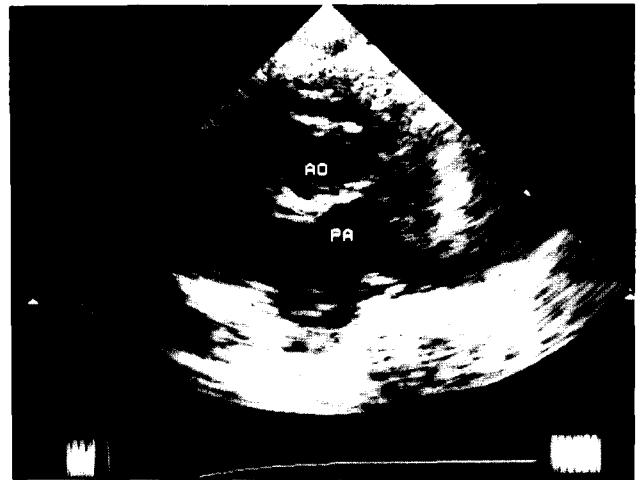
(Case 2.) Preoperative echocardiogram (short axis view at the great artery level) showing that the aorta is located in the right anterior portion of the main pulmonary artery.
